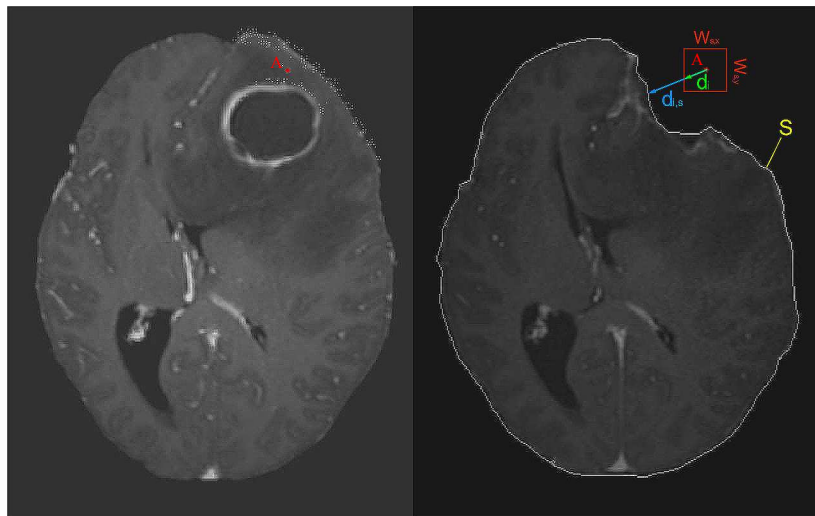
The PCBM module on a pair of brain MRIs. Left: pre-operative MRI. The white points on the top right of the left figure represent the blocks without a correspondence. Point A represents one of those blocks. Right: intra-operative MRI. \mathcal{S} : the points on the target brain surface; $d_{i,\mathcal{S}}$: Euclidian distance vector from the center of the block to its closest point on \mathcal{S} ; d_i : Euclidian distance vector bounded by the block matching window W .
